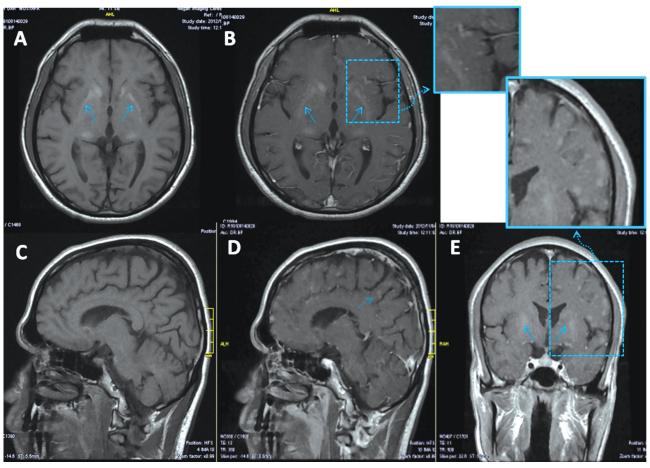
T1-weighted 1.5 T MR-images of the brain of a 20-year-old MELAS case (A:axial view, C:sagittal view), after Gadolinium-enhancement showed nodular cortical enhanced lesions (B:axial view, D:sagittal view and E:coronal view). Bilateral basal ganglia calcification is also shown on the images (arrows in A, B and E).
